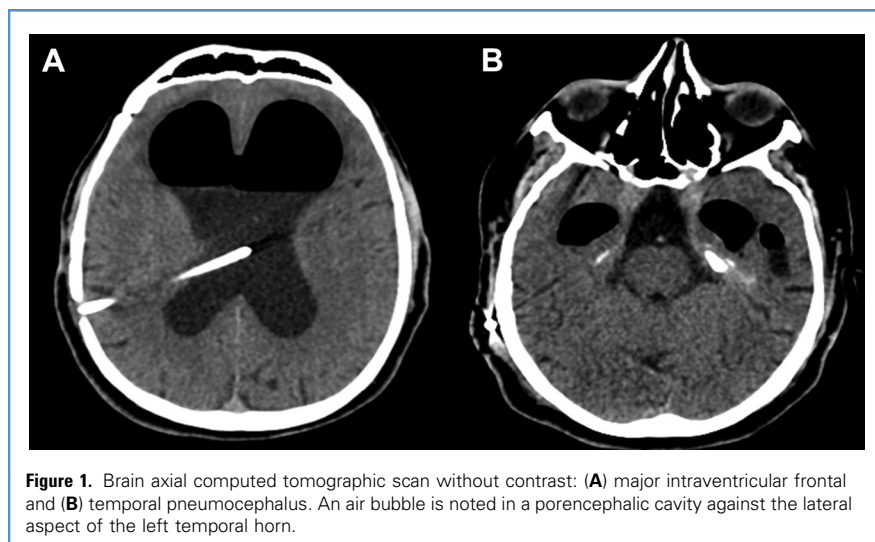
Brain axial computed tomographic scan without contrast: (A) major intraventricular frontal and (B) temporal pneumocephalus. An air bubble is noted in a porencephalic cavity against the lateral aspect of the left temporal horn.
